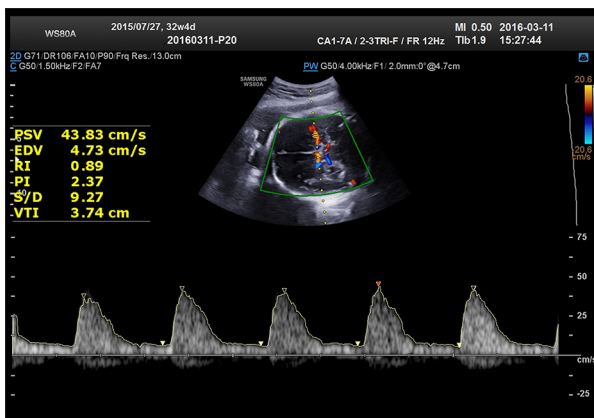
Ultrasound Doppler spectrum of fetal MCA in the control group.
